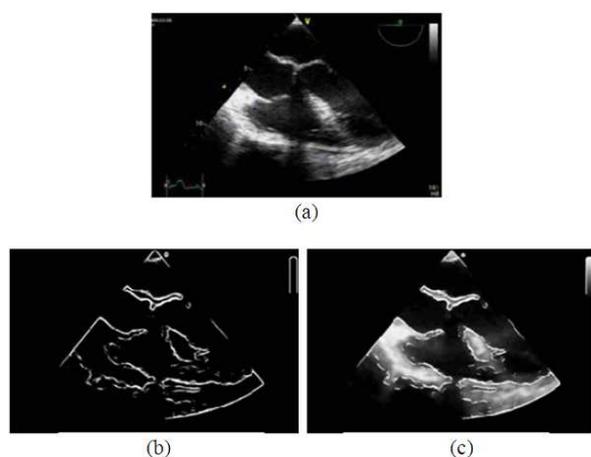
Finalized Echocardiograph Image (a) Original (b) Contour detected (c) Result
